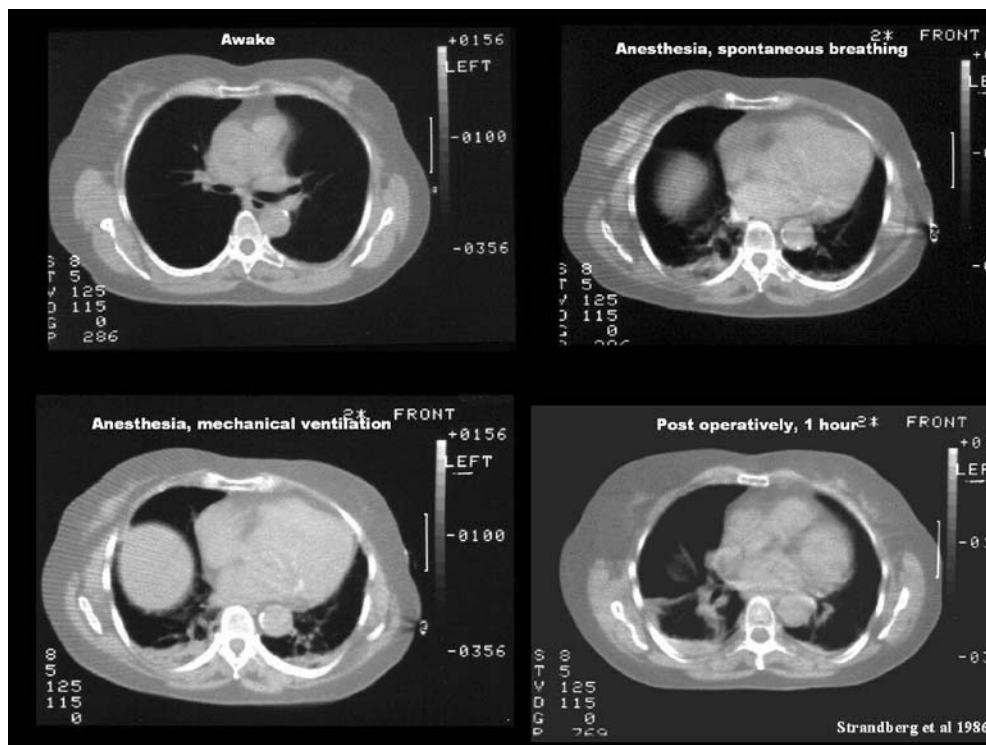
Computed tomography in a subject when awake (*upper left*), during anesthesia with spontaneous breathing (*upper right*), after muscle paralysis (*lower left*), and 1 h postoperatively (*lower right*). Note the appearance of atelectasis already during spontaneous breathing during anesthesia with a slight further increase with mechanical ventilation (mainly explained by the end-expiratory exposure in the paralyzed subject whereas during spontaneous
